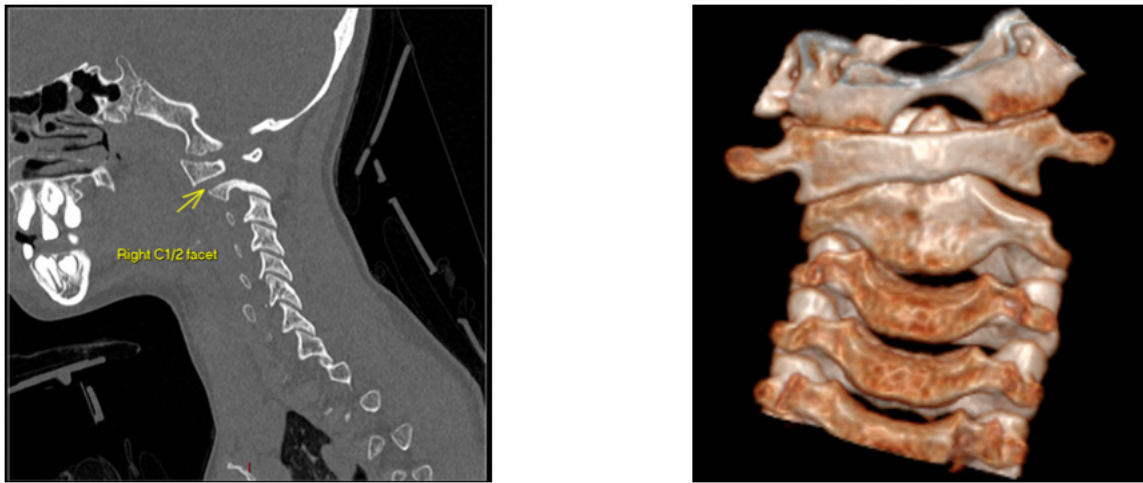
Index CT scan images of our second patient. A 3-dimensional reconstruction of the CT scan (left) confirmed that the right C1 facet is placed anterior to the C2 facet and the left C1 facet is placed posterior to the C2. The odontoid process was not central within the anterior arch of C1 and was mildly displaced to the left. A sagittal view of the cervical spine (right) confirmed this. The remainder of cervical spine maintained a normal alignment and no injury to bone nor soft tissue was noted.
